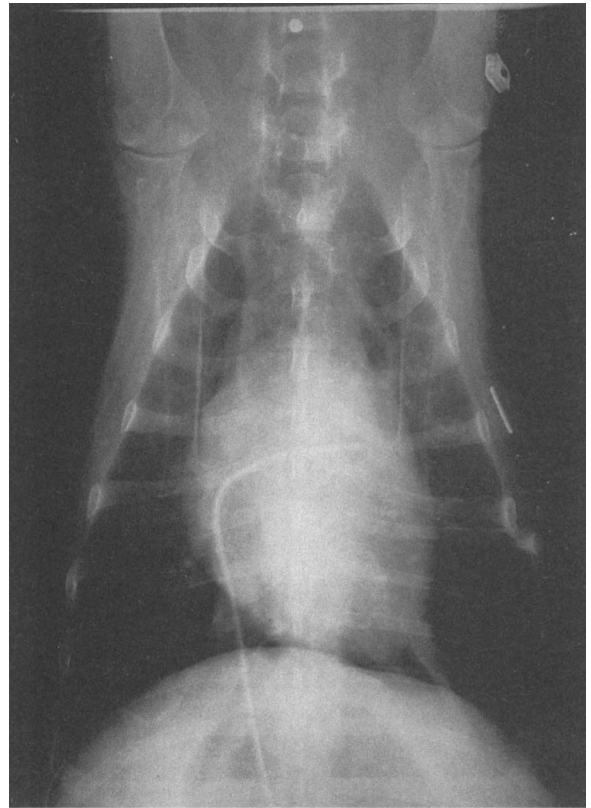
Chest roentgenogram of a recipient (No. 46) 22 days after receiving a transplant of a left lung preserved for 24 hours with LPDG solution and implanted with pulmonary cooling jacket. No significant abnormalities are seen in lungs.
